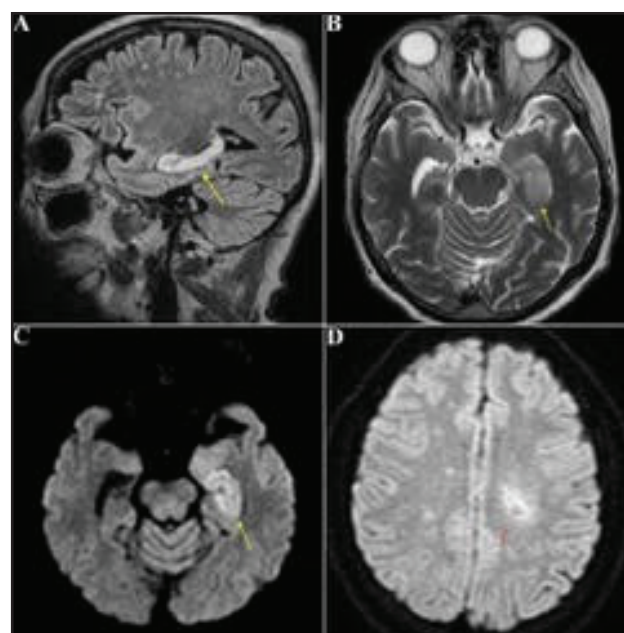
Brain MRI: MRI demonstrates unilateral increased FLAIR (A) and T2 (B) signal intensity of the left mesial temporal lobe; DWI hyperintensity (C) without hypointense correspondent on the ADC map (D).
